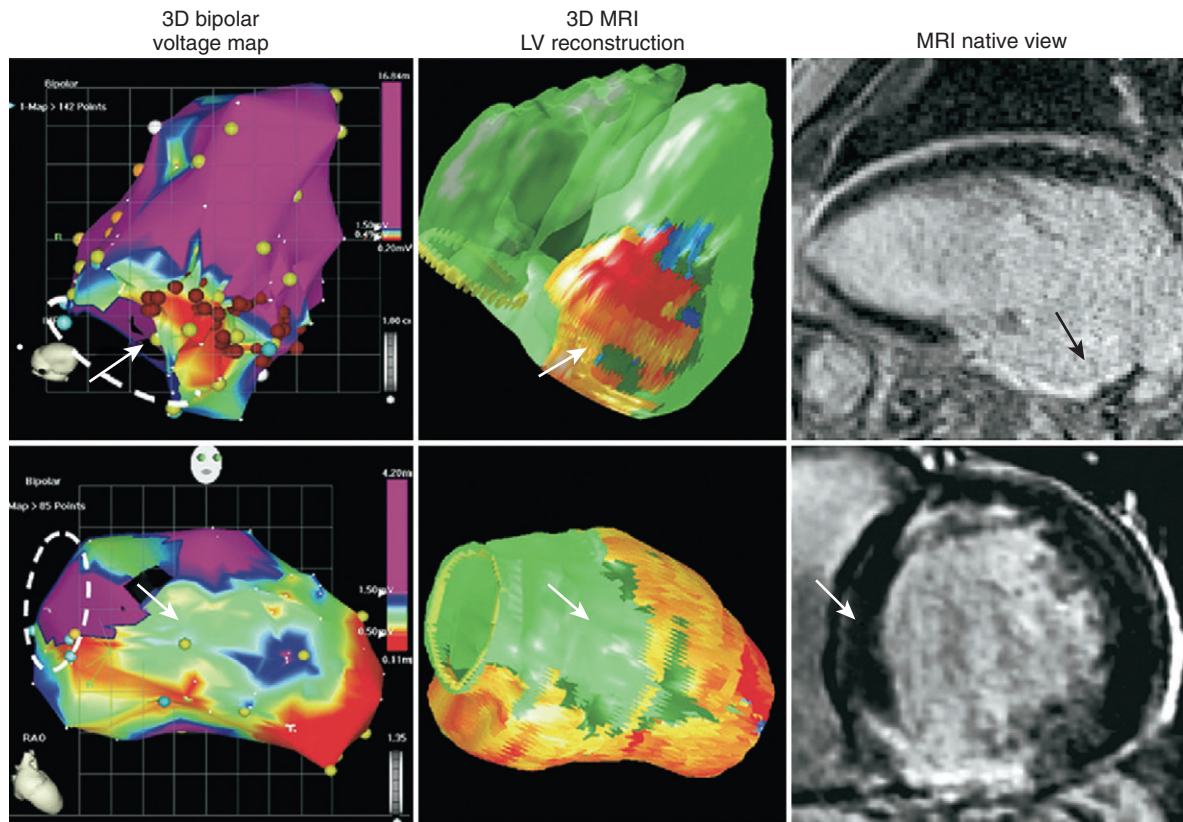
Mismatch in scar delineation between CARTO bipolar maps and magnetic resonance imaging (MRI) shells. *Left*, CARTO bipolar maps; *(middle)* MRI shells; *(right)* native MRI images. The top row shows the underestimated inferior wall scar on the CARTO map. The bottom row shows the left ventricular septal scar on the CARTO map not confirmed by MRI. On each panel, the arrows show the mismatch zone. The dotted lines represent the mitral annulus plane. LV, left ventricle. (From Codreanu A, Odille F, Aliot E, et al: Electroanatomic characterization of post-infarct scars comparison with 3-dimensional myocardial scar reconstruction based on magnetic resonance imaging, *J Am Coll Cardiol* 52:839, 2008.)
